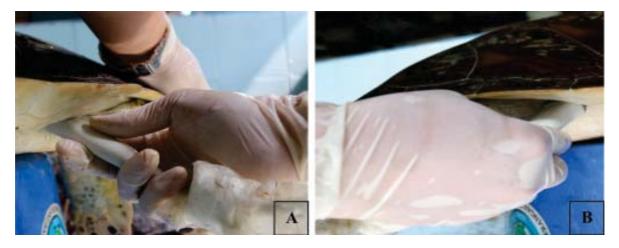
and 6B. Ultrasound Evaluation of the Prefemoral Acoustic Window. (Fig 6A) Ultrasonography Imaging of Left Prefemoral was Taken By Transverse (Fig 6B) Ultrasonography Imaging of Right Prefemoral was Taken By Transverse.
